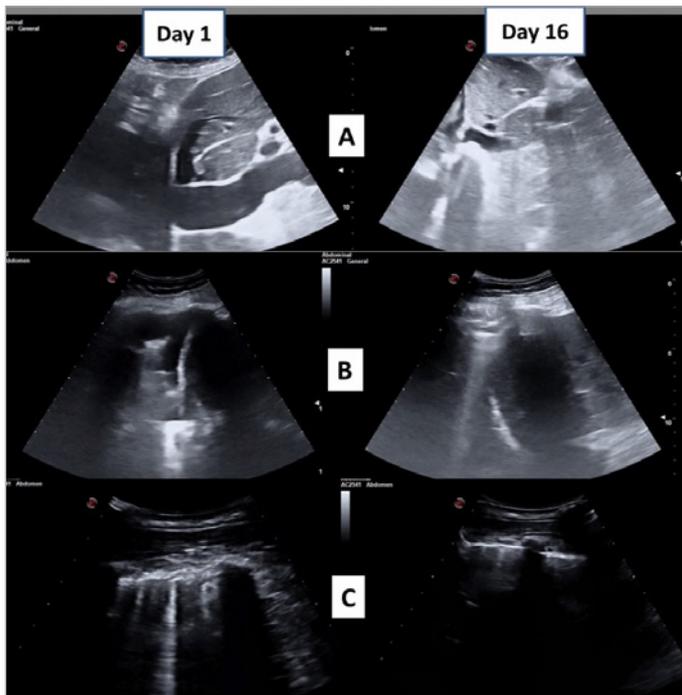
Comparative ultrasound evolution of congestion between days 1 and 16 of treatment. A: Inferior vena cava decongestion. B: Resolution of pleural effusion. C: Elimination of significant B-lines in lung parenchyma.
